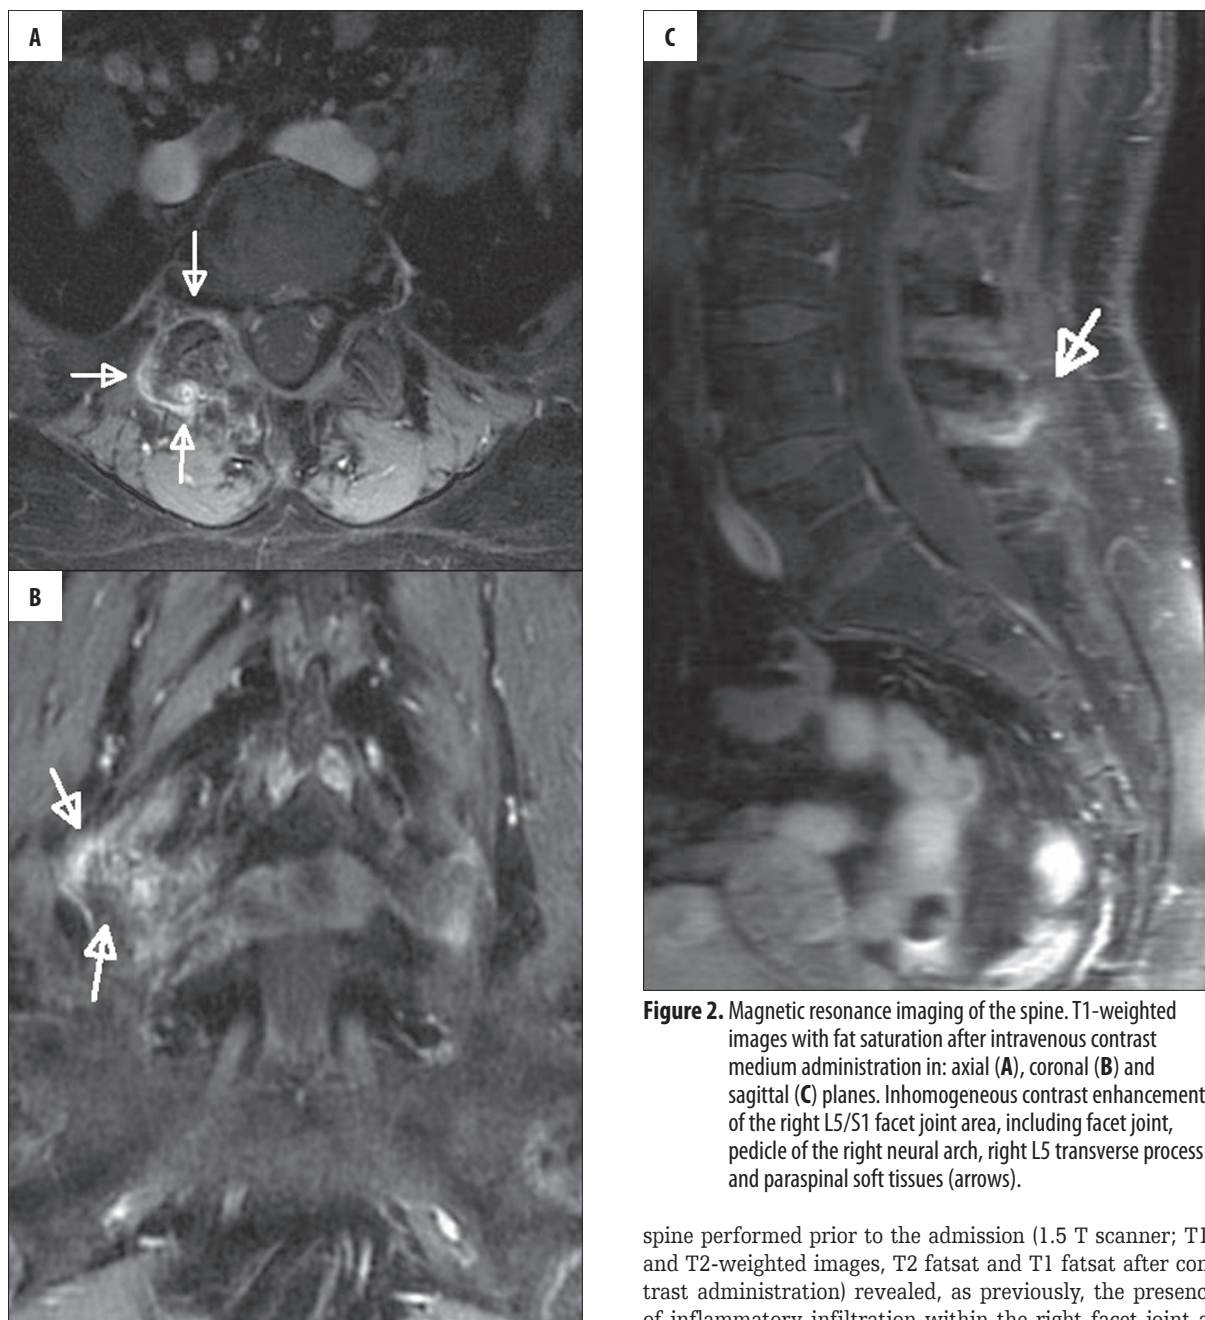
Magnetic resonance imaging of the spine. T1-weighted images with fat saturation after intravenous contrast medium administration in: axial (A), coronal (B) and sagittal (C) planes. Inhomogeneous contrast enhancement of the right L5/S1 facet joint area, including facet joint, pedicle of the right neural arch, right L5 transverse process and paraspinal soft tissues (arrows).
